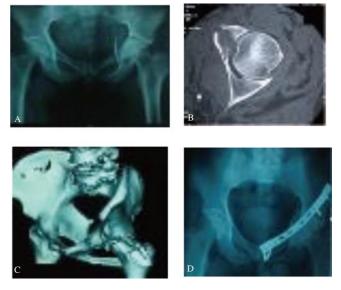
Postoperative radiographic reduction quality of a patient applying Stoppa approach.
